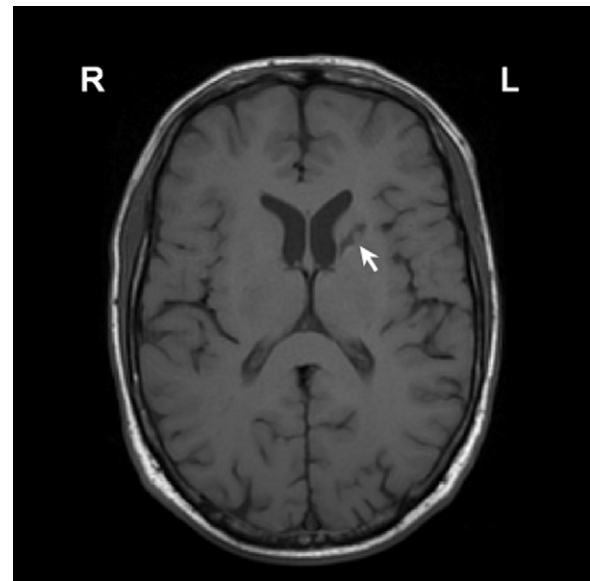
Axial T1-weighted magnetic resonance image showing a hypodense lacunar lesion in the genu and anterior limb of the left internal capsule, involving a portion of the putamen (arrow).
